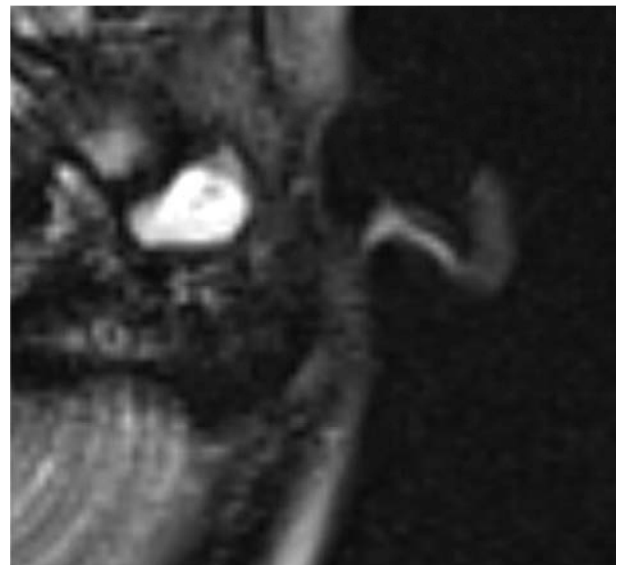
Axial T2-Weighted MRI with evidence of an expansile mass located in the right external ear canal.
